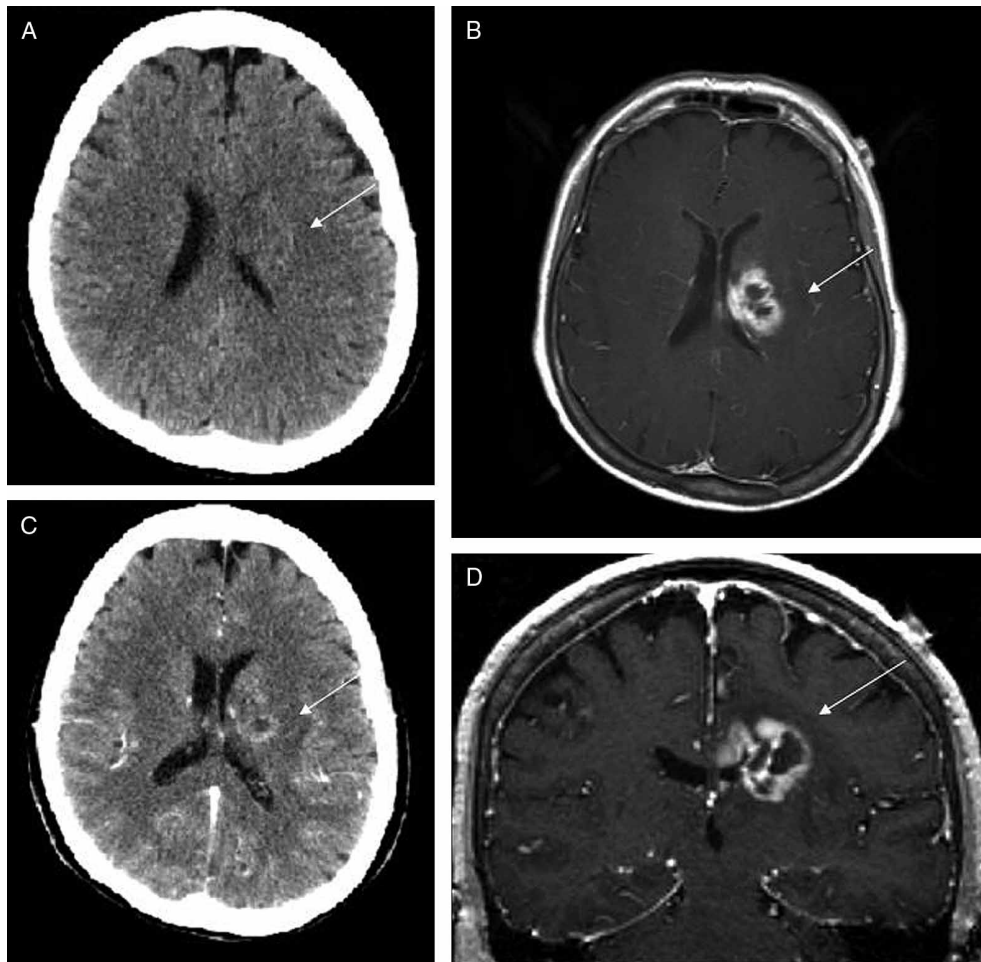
Initial imaging of lesion. (A) Axial section of native CT-Scan demonstrating a discrete hypodensity in the left body of the caudate and mass effect on the lateral ventricle. (B) Contrast-enhanced CT-Scan showing enhancement of the lesion. (C) Axial section of contrast-enhanced T1-weighted MRI. (D) Coronal reconstruction of contrast-enhanced T1-weighted MRI showing extension within corpus callosum.
